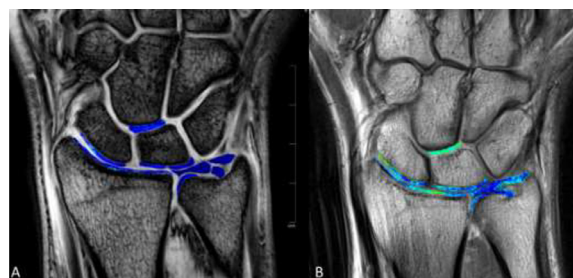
Image analysis. 3T MRI images of the first echo of the T2* (A) and T2 (B) MEGE/MESE sequence of a healthy control with superimposed color-coded maps of T2* and T2 values. Regions of interest (ROI) were placed at the cartilage of the distal radius, the proximal scaphoid, the proximal radial and ulnar lunate, the distal radial ulnar joint and in-between the distal lunate and proximal capitate. Three ROIs were placed at the triangular fibrocartilage complex: at the central disc, and at both the foveal and the apical attachment. The same analysis was also performed at 7T MRI.
